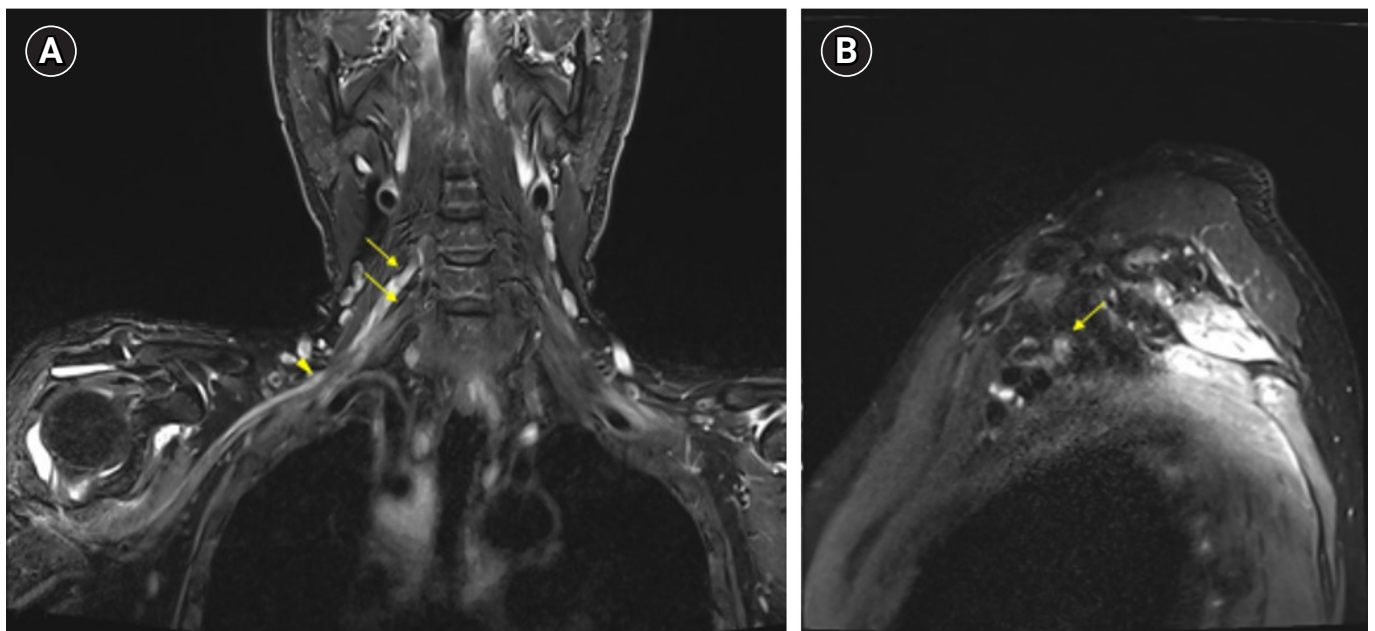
Contrast-enhanced coronal T2-weighted brachial plexus magnetic resonance imaging. (A) Edema and enhancement of right C5 and C6 nerve roots (arrows) and edema of the upper trunk of the brachial plexus (arrowhead). (B) Edema at the right posterior cord level of the brachial plexus (arrow).
